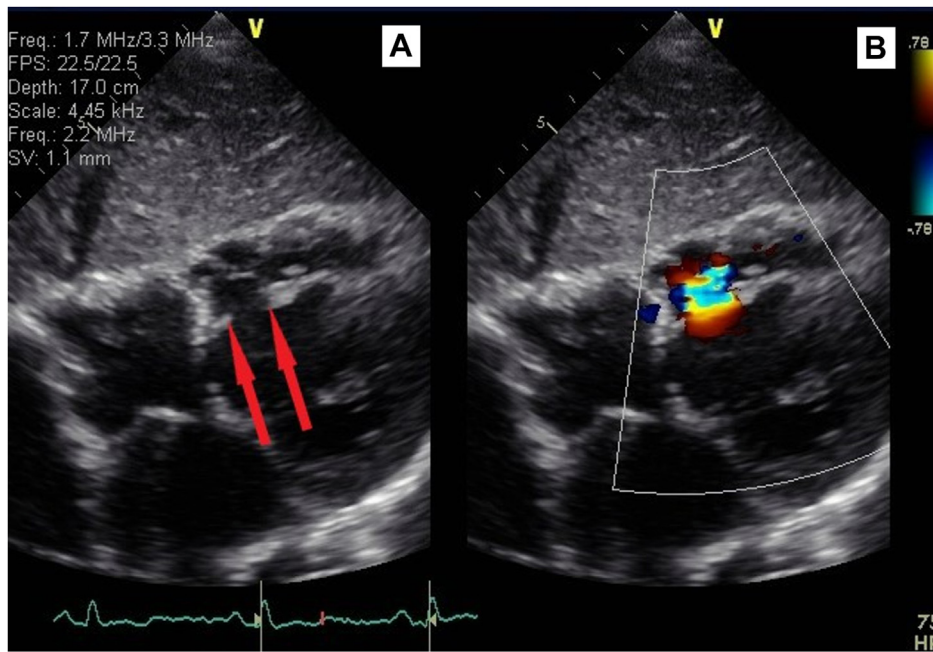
Transthoracic echocardiogram. A: Subxiphoid view showing a large ventricular septal perforation wherein the red arrows mark edges. B: Color Doppler shows flow through the defect.
